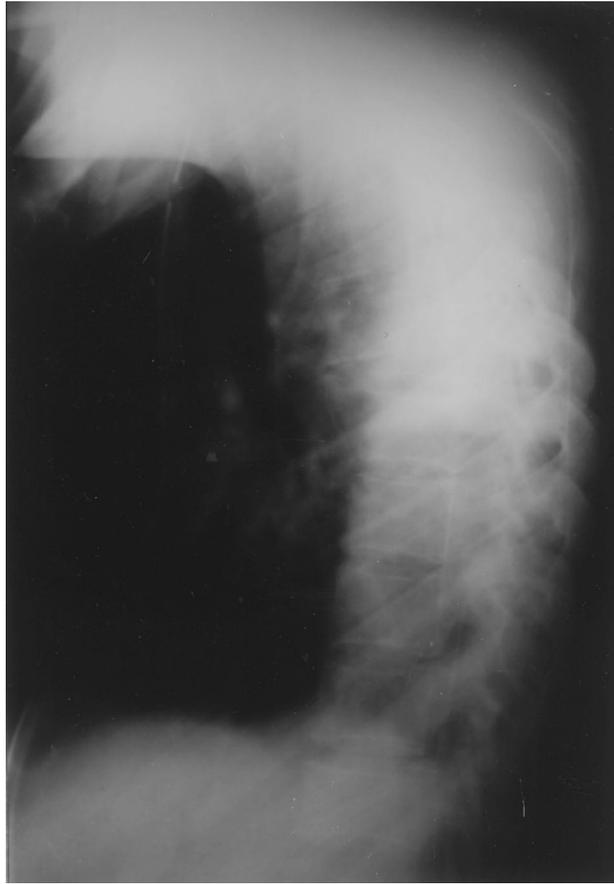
Lateral X-ray showing displaced fracture–dislocation at T4.
